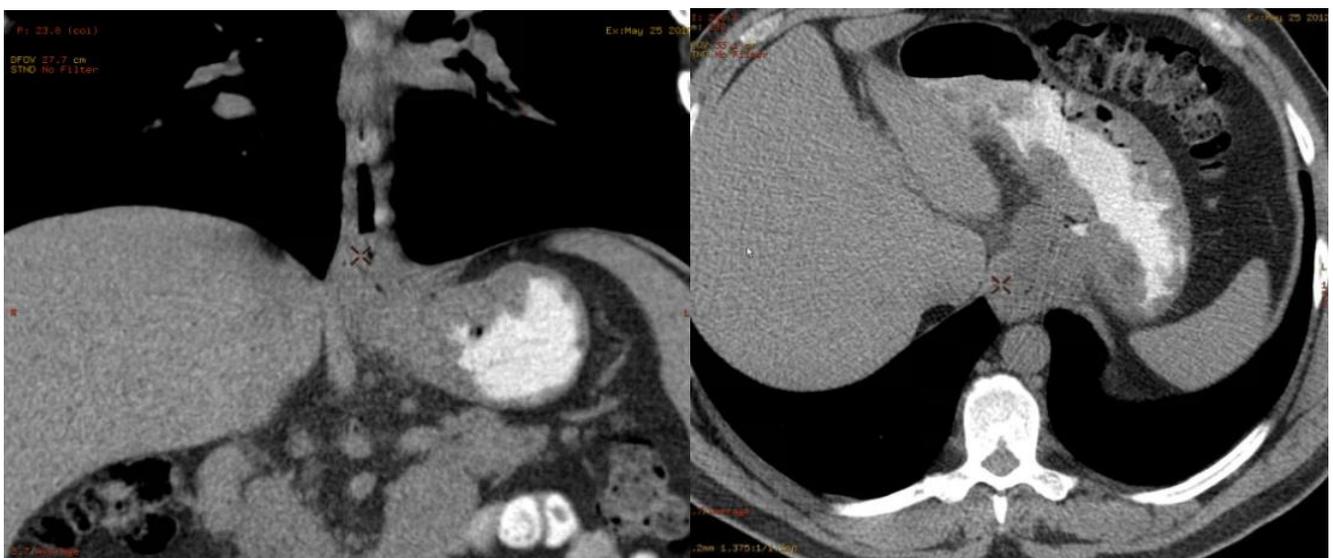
Initial CT showing a stenosing esophagogastric bulky mass.
